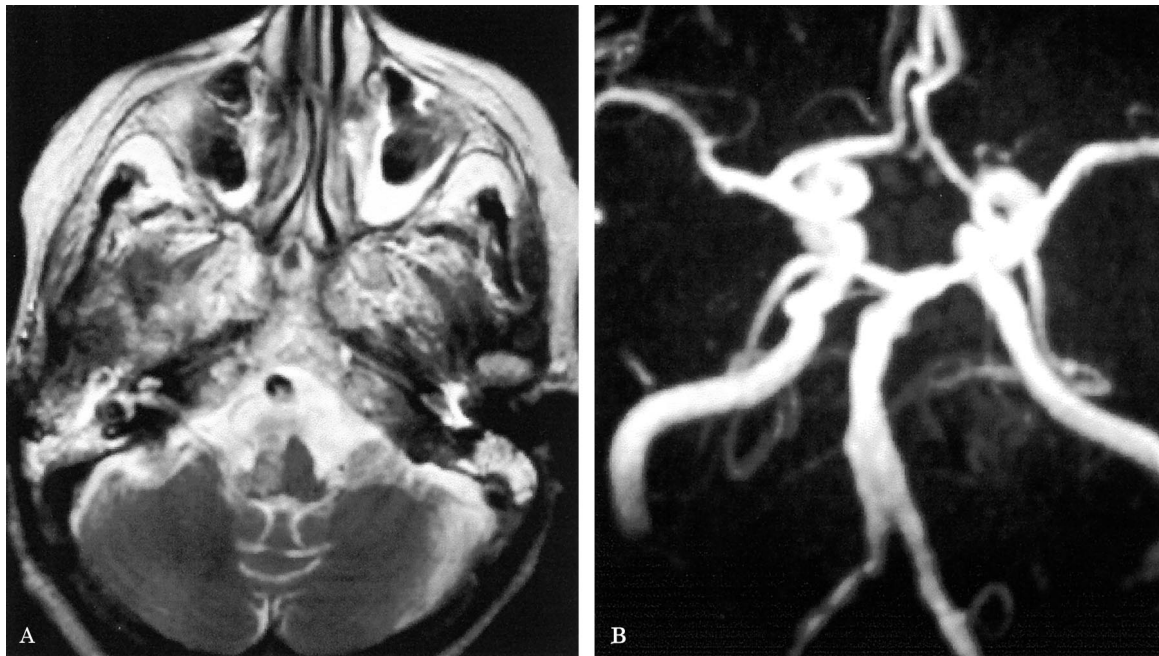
weighted MRI section of the medulla shows an infarct involving the right hemimedulla (A). MR angiography shows severe stenosis of the terminal segment of the right vertebral artery (B).
